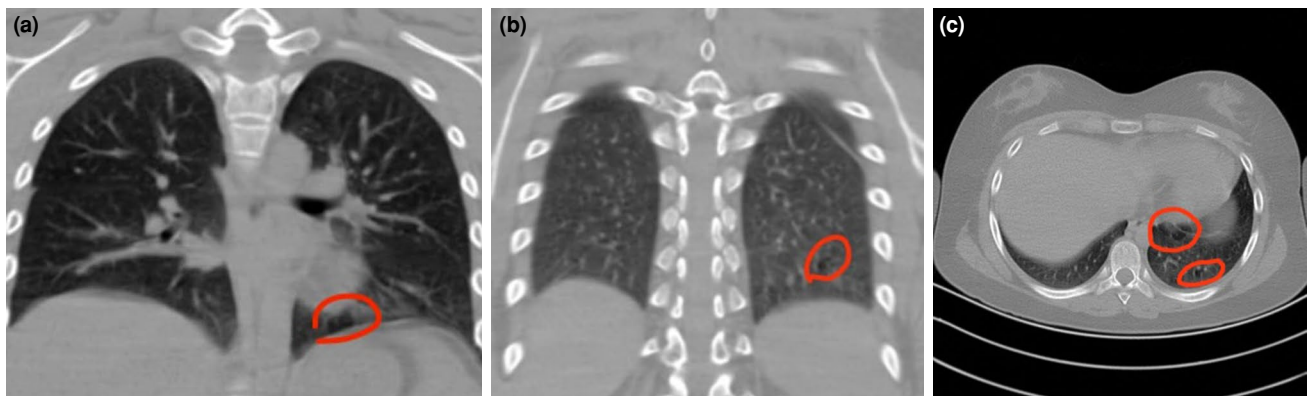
Pulmonary computed tomography views, emphysematous areas highlighted in red circles. (a, b) Coronal view of the thorax. (c) Axial view of the thorax.
